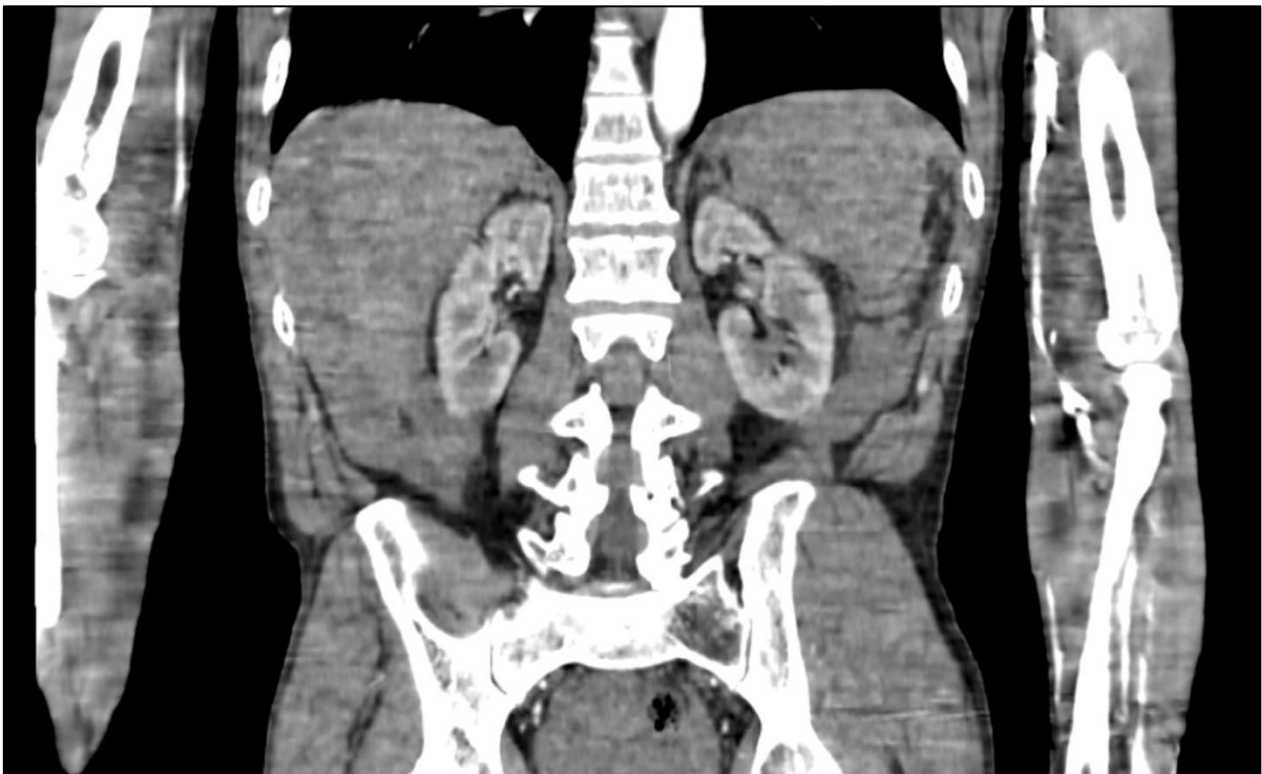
Coronal section of the abdominal CT scan showing the splenic rupture with the deformities and the hemoperitoneum
